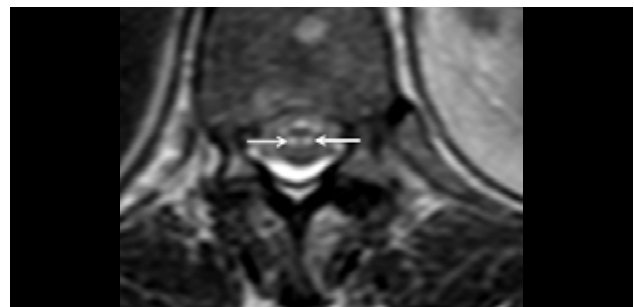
MRI of a 45-year-old man presenting with flaccid limb paralysis and hyporeflexia. Axial T2WI sequence of the thoracic spinal cord showing hyperintense signals in the ventral horns. This appearance represents the motor neuron pattern, a radiologic sign characterized by symmetric involvement of the anterior horn cells on axial T2WI.
